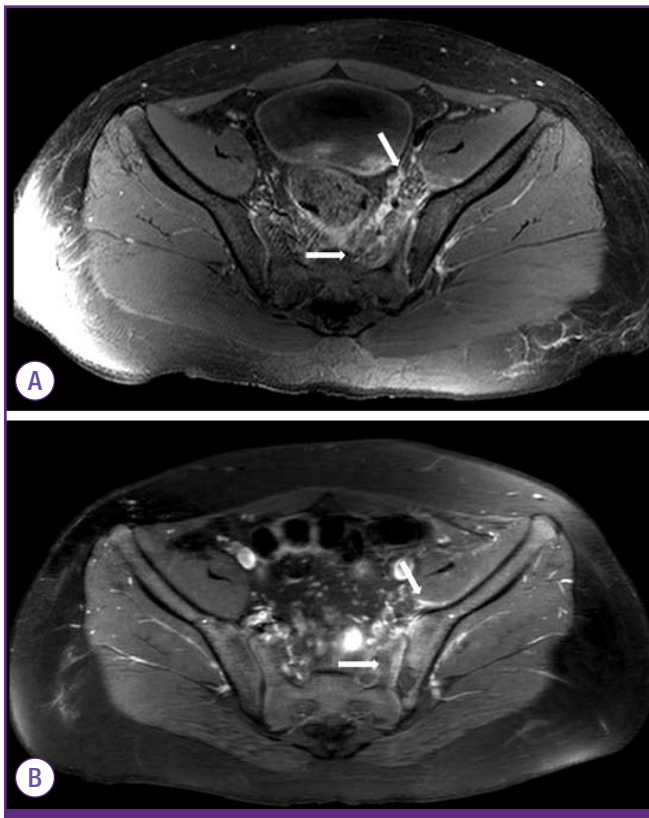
Fat-suppressed axial T1-weighted magnetic resonance images of sacroiliac joints showing synovitis and capsulitis of the left sacroiliac joint with extra-articular extension to the left iliacus muscle and iliac vessels on the third hospital day (A) and improvement in the extra-articular soft tissue inflammation but aggravated subchondral inflammation on the 13th hospital day (B) (arrow).
